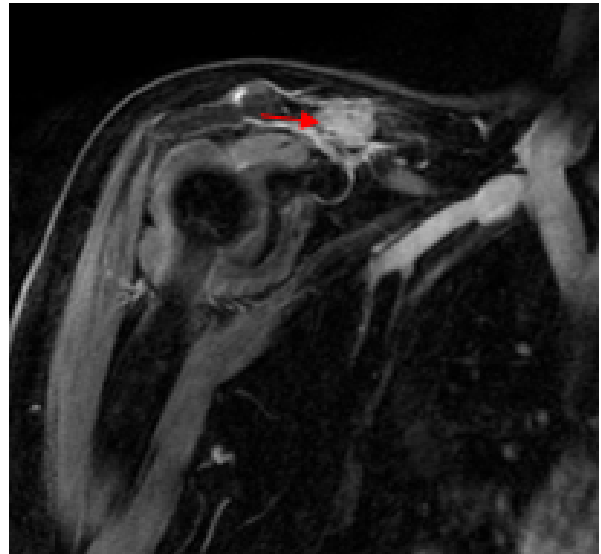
Coronal postcontrast T1w shoulder MRI showing obviously enhancing metastatic lesion of the right clavicle (arrow)
